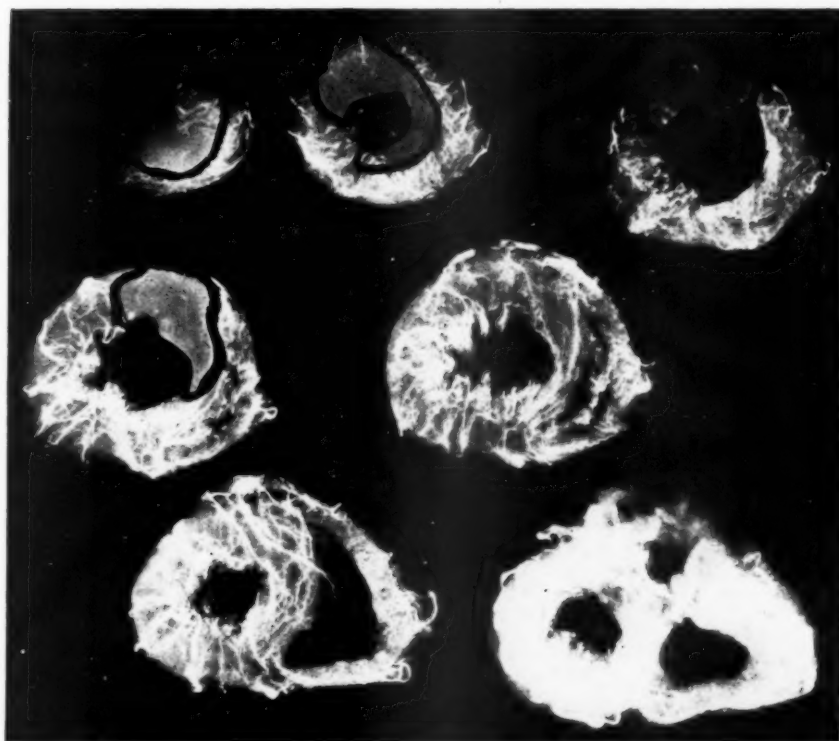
Roentgenogram of the injected heart of Case 20.
